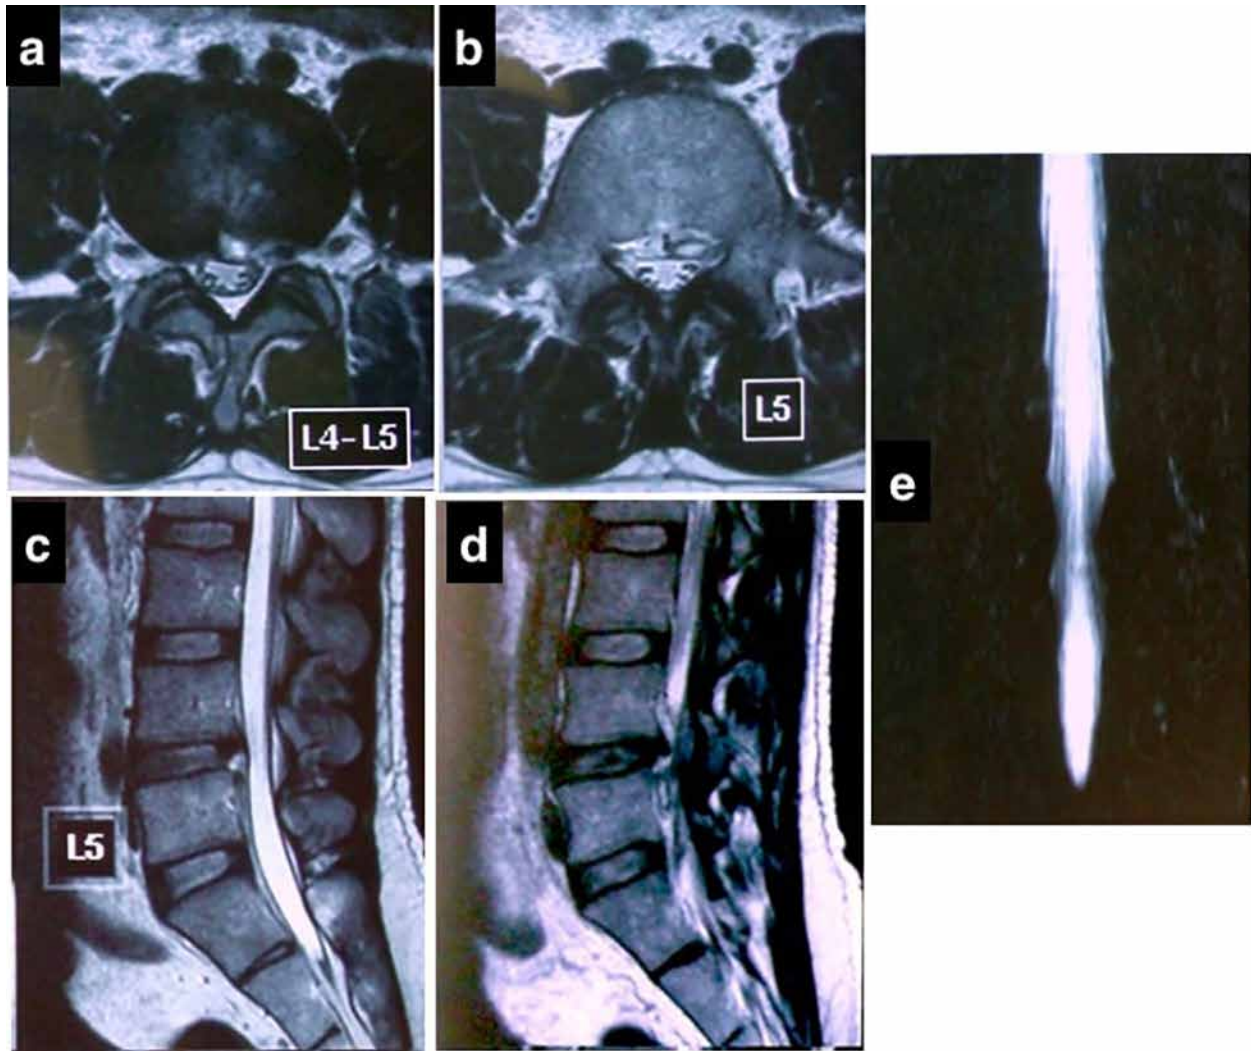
Immediate postoperative MRI: (a,c) T2-weighted image, axial coplanar at disc level & T2-weighted midsagittal image showing the central-to-paracentral subannular disc fragment completely removed. (b,d,e) T2-weighted image, axial-at-pedicle level, parasagittal image & MR myelogram showing the disc cyst removed. Clinically at 6-year follow-up the patient is symptom-free.
